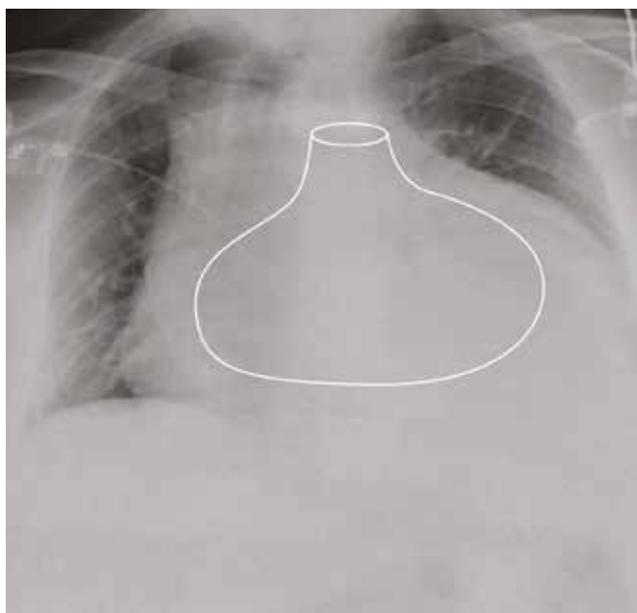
Chest X-ray of the patient demonstrating the 'water bottle sign'
